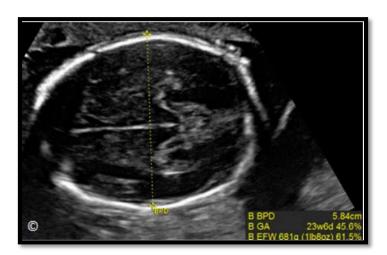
A 2 – D ultrasonography of the fetal skull at 23weeks, 6 days of gestation at the biparietal diameter (BPD) level (Ultrasound in Obstetrics and Gynecology: A Practical Approach | Textbook | GLOWM, n.d.)
